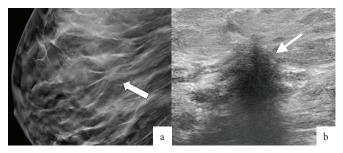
Suspected lesion (arrow) on mammogram (a) was clearly confirmed on breast ultrasound (b).
